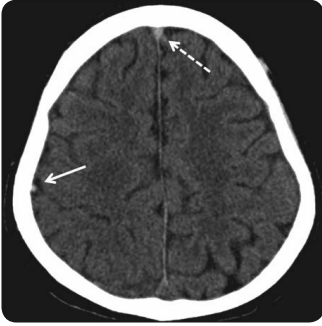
Axial non-contrast CT-scan of a 27-year-old man with CVT. He had a history of acute lymphoblastic leukemia and presented with generalized seizures. Note the hyperdense signal in the anterior part of the superior sagittal sinus (delta sign; dashed arrow) and in one of the cortical veins overlaying the right hemisphere (cord sign; filled arrow).
